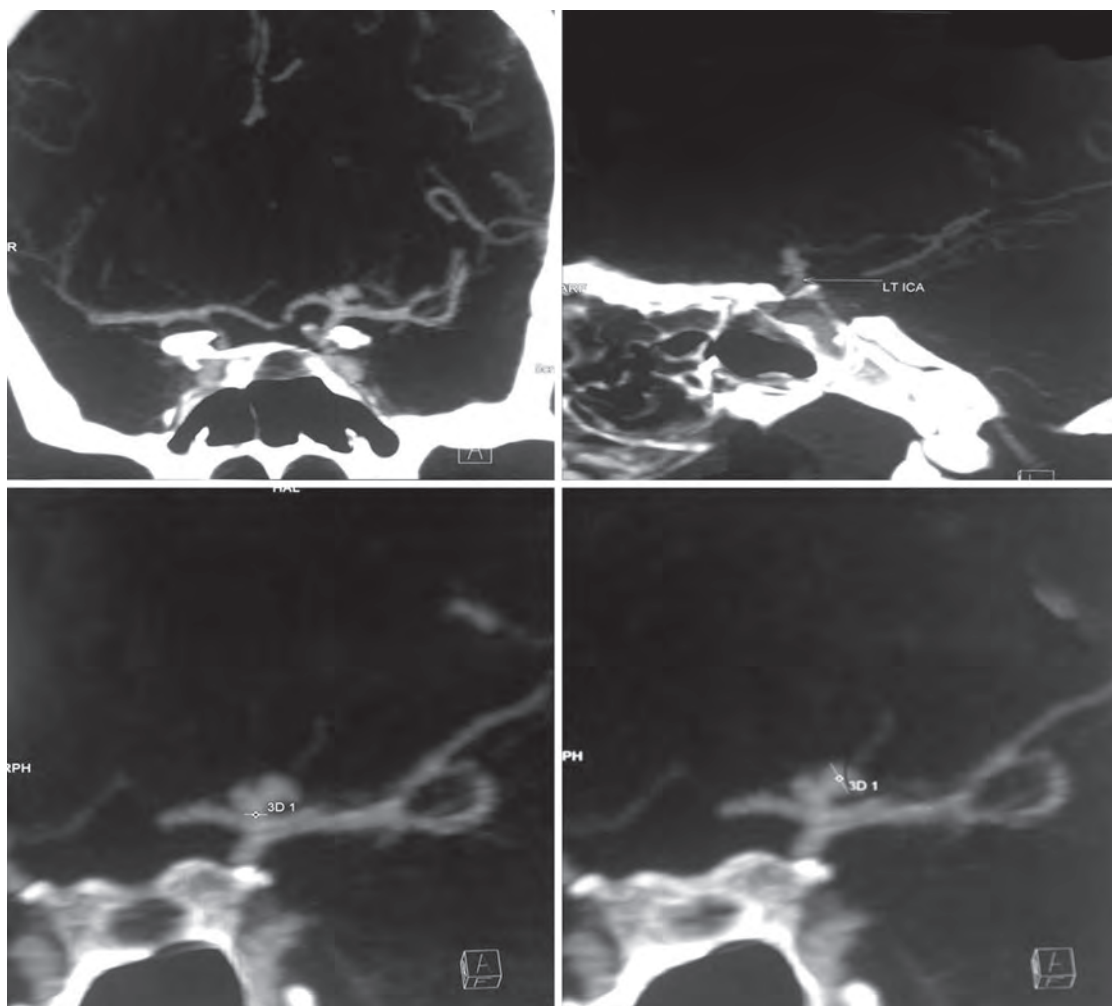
CTA showing bilobed ICBA
